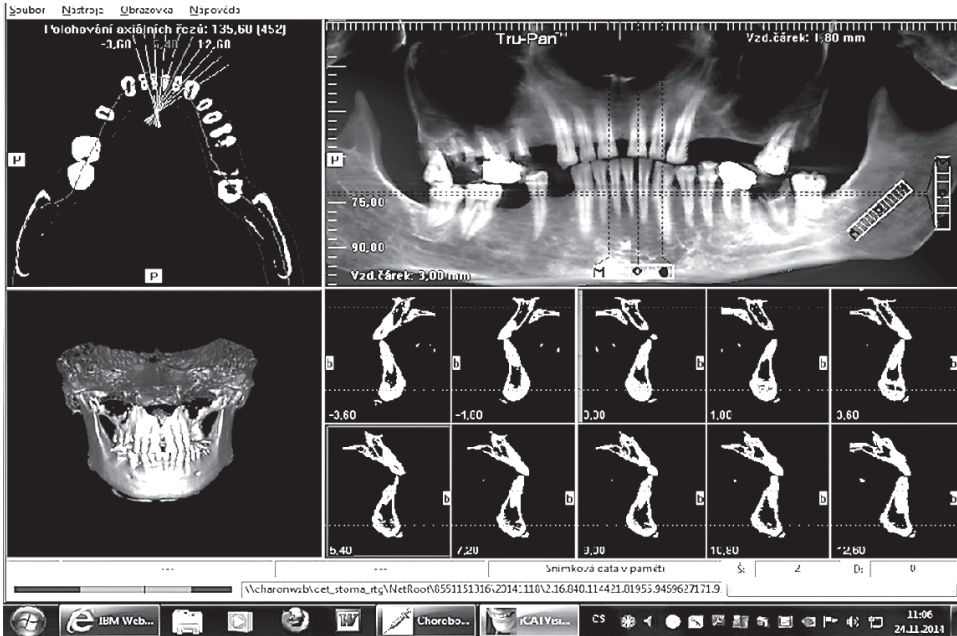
Cone-beam reconstruction including generated orthopantomogram.
